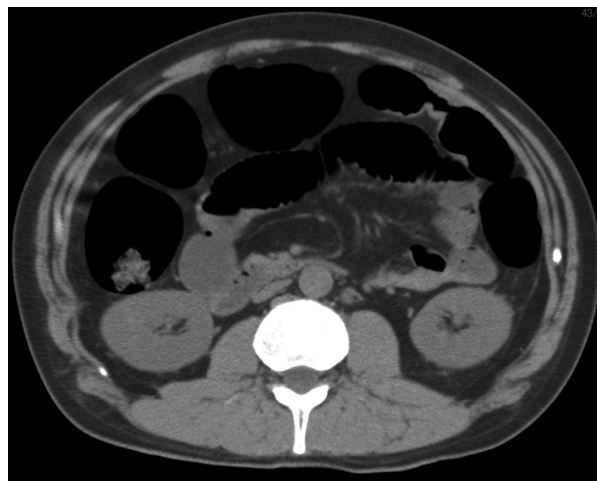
Abdominal CT findings. An computed tomography image without contrast medium-enhance shows dilatation along the full length of the colon, with partial niveaus, but without intestinal dilatation, volvulus, or a tumor mass.
